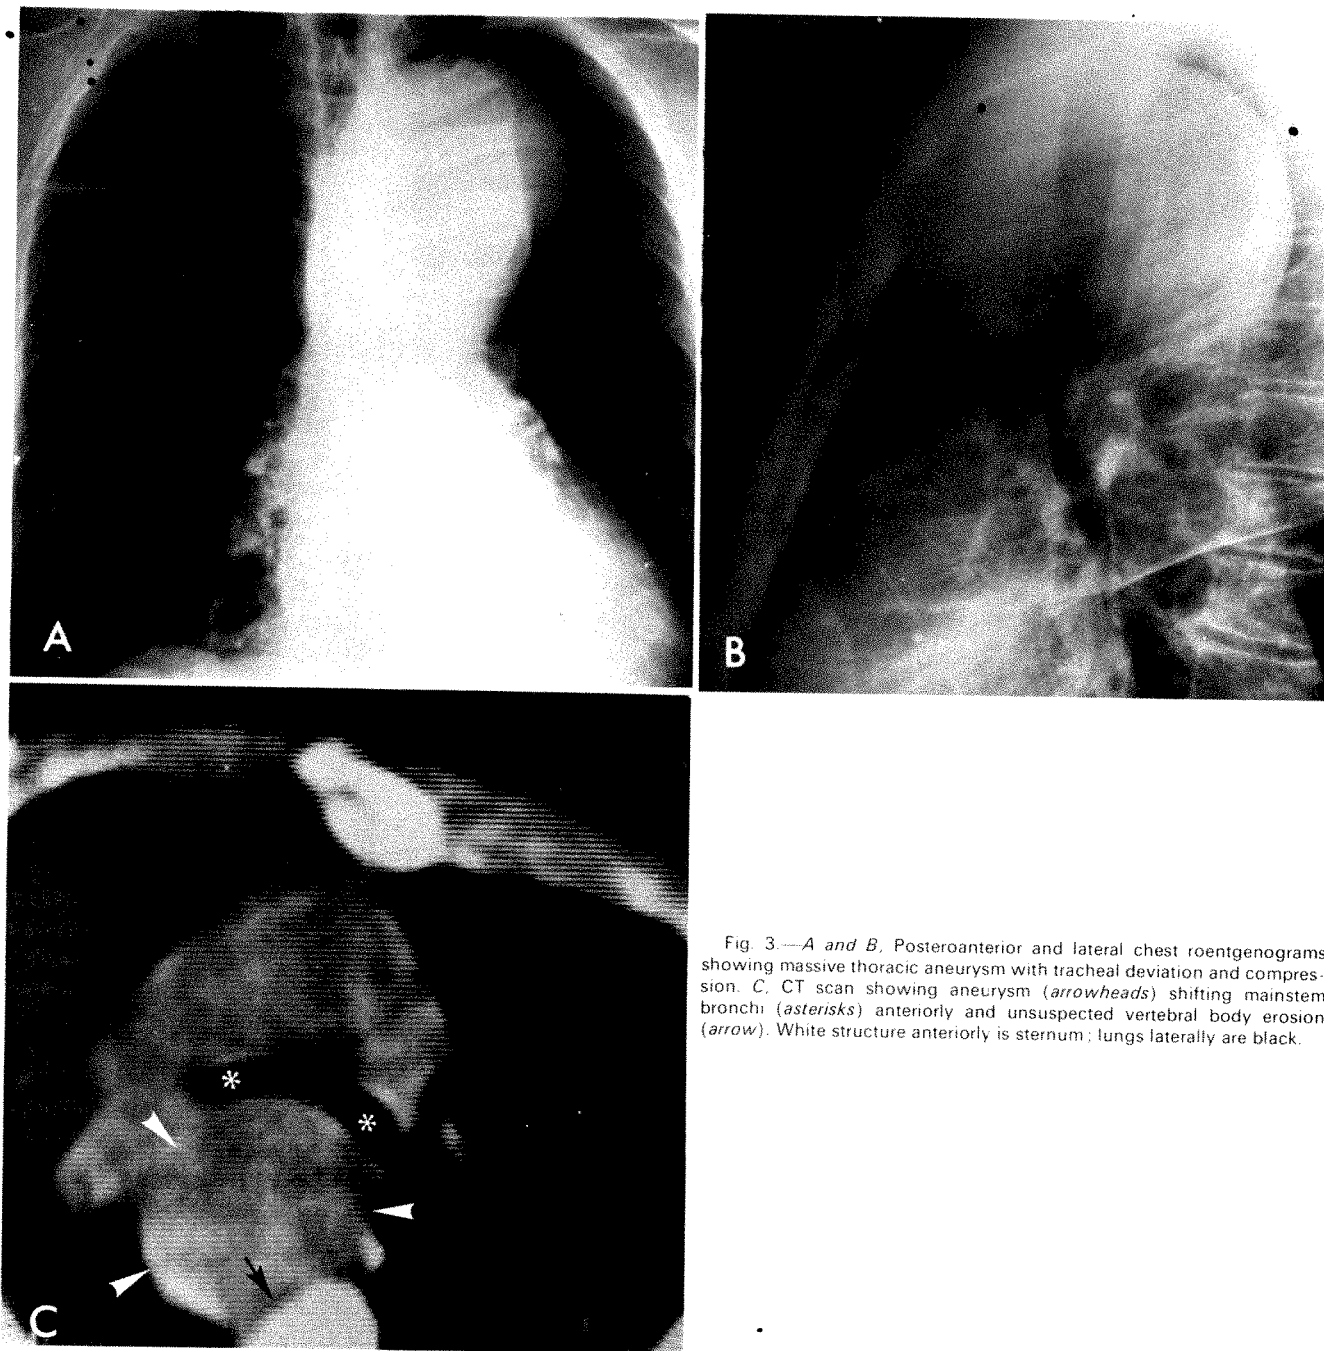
A and B*, Posteroanterior and lateral chest roentgenograms showing massive thoracic aneurysm with tracheal deviation and compression. *C*, CT scan showing aneurysm (*arrowheads*) shifting mainstem bronchi (*asterisks*) anteriorly and unsuspected vertebral body erosion (*arrow*). White structure anteriorly is sternum; lungs laterally are black.
